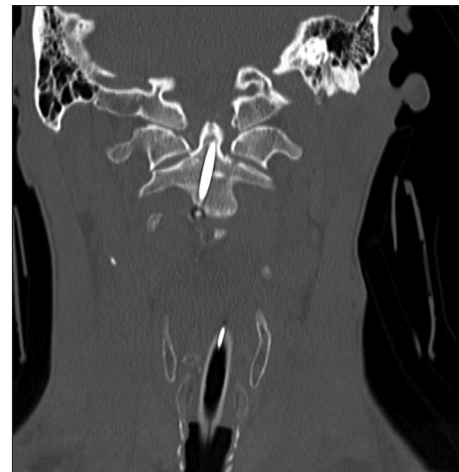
Coronal immediate post-anterior odontoid screw fixation computed tomography images of the cervical spine, demonstrating near anatomic correction of the patient's type II odontoid fracture with a lag screw.
